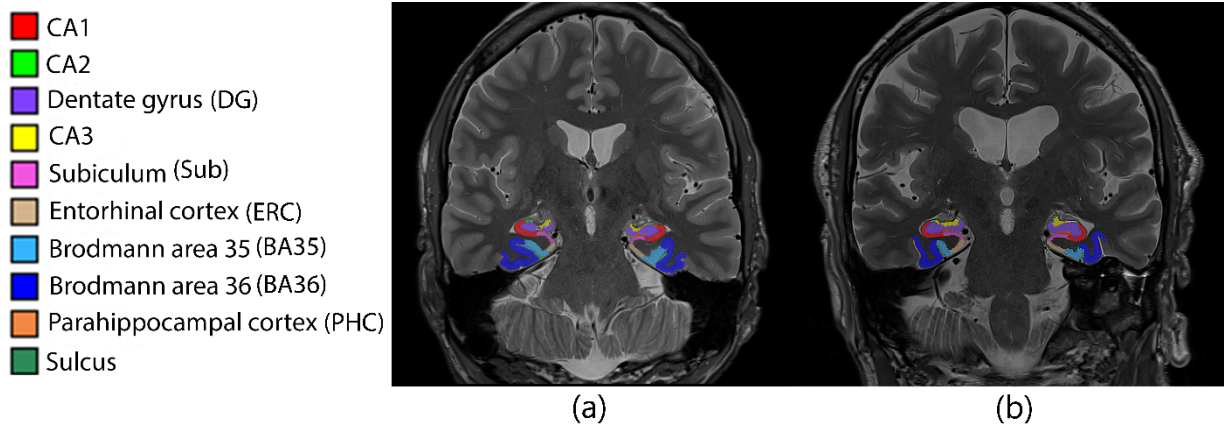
Two examples subjects with the hippocampal subfields segmented using the ASHS software overlaid on a T2-weighted image (T2W) of one younger subject (a) and one older
